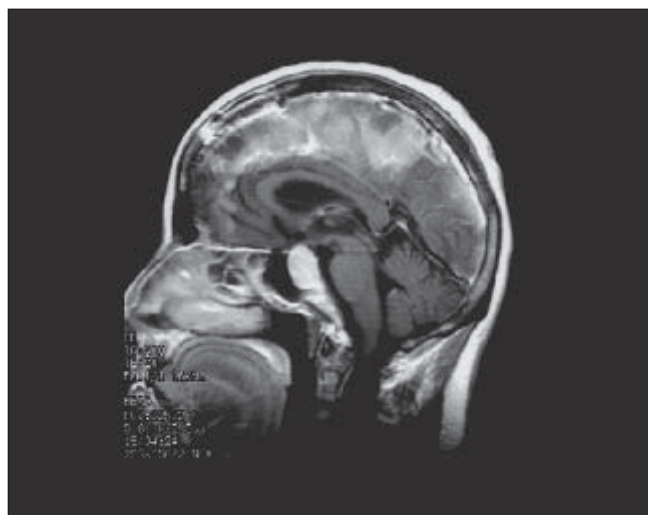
MRI (with contrast) showing the parasellar meningioma.
